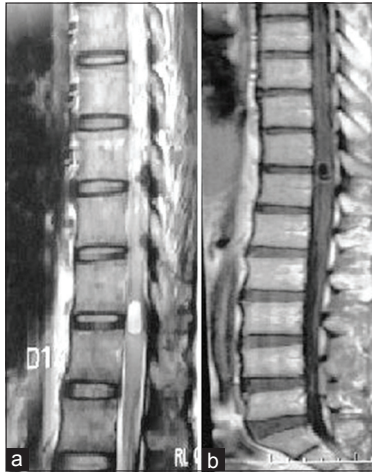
(a) T2W1 magnetic resonance image (MRI) showing hyperintense cystic intramedullary lesion at D11-D12 disc level. (b) Contrast T1W1 MRI showing hypointense cystic intramedullary lesion with peripheral rim enhancement on sagittal cut
